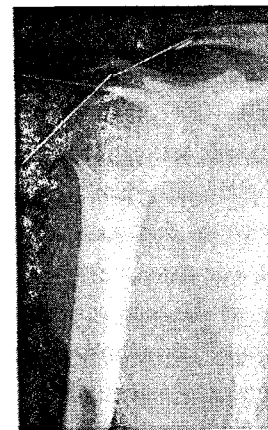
Compiled X-ray 1
